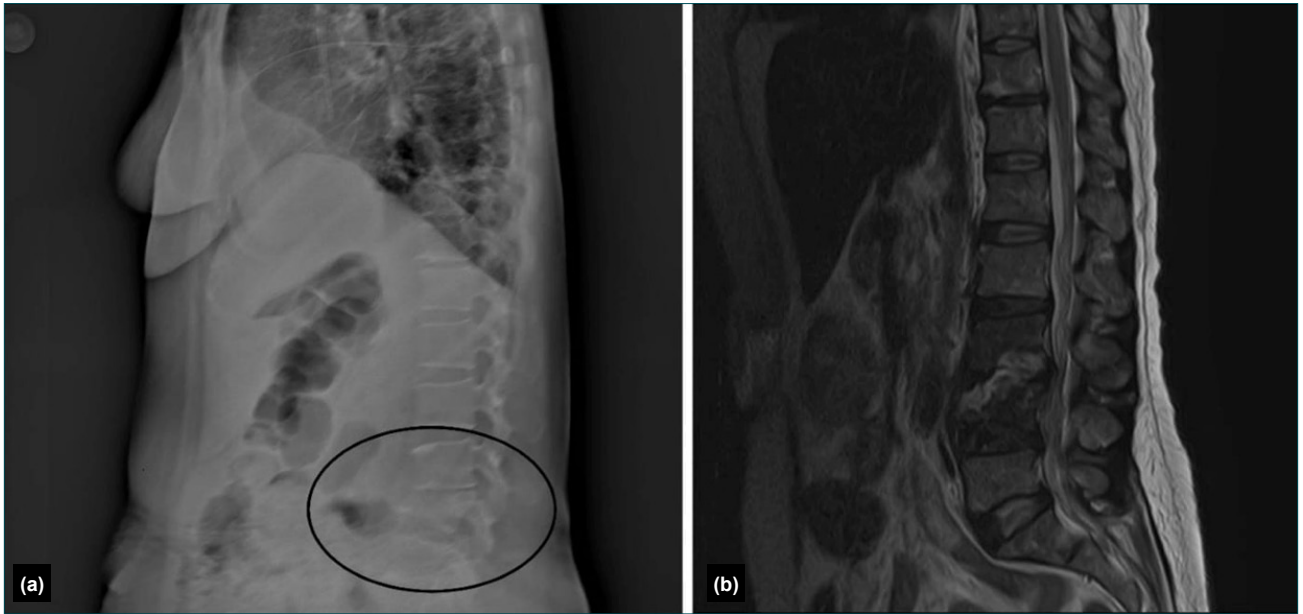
(a) X-ray demonstrated vertebral body collapse at L4, irregularity of the L3–L4 disc space, and disruption of lumbar spinal alignment (outlined area in the figure). Based on these findings, the patient was referred to the relevant specialists with a differential diagnosis of spondylodiscitis. (b) Lumbar spine magnetic resonance imaging (MRI), performed after hospital admission, supported a preliminary diagnosis of spinal abscess. The patient subsequently underwent surgical intervention by the neurosurgery team. The preoperative C-reactive protein (CRP) level was 140 and decreased to 34 after two weeks of antibiotic therapy.
